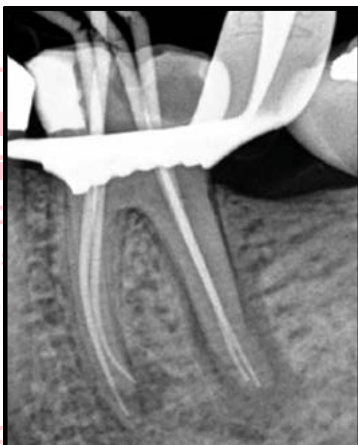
Master cone radiograph. The four separate canals are terminating at different lengths. It would not have been possible to estimate this accurately using a preoperative radiograph only, and an apex locator with radiograph was essential
